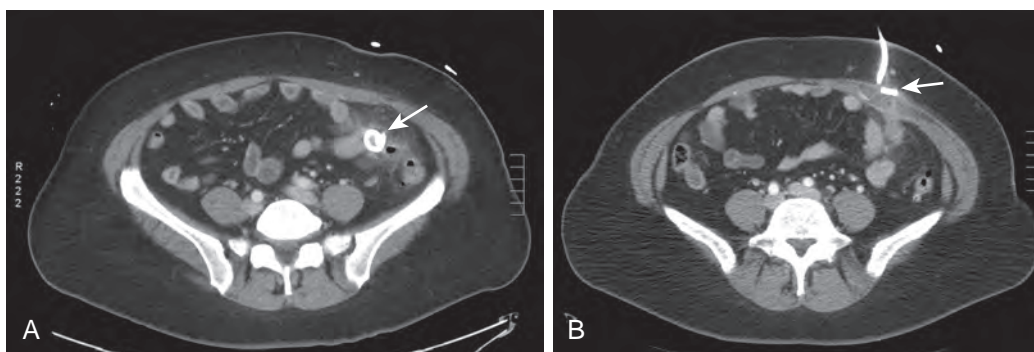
Catheter dislodgment after percutaneous drainage. A. Axial CT image shows a left lower quadrant percutaneous drainage catheter placed in a 65-year-old man with diverticular abscess. The catheter tip is in the appropriate position within the abscess (arrow). The patient presented 2 weeks later with decreasing drainage from the catheter. B. Follow-up CT showed that the catheter had retracted from an intra-abdominal location into the subcutaneous tissues (arrow). The catheter was successfully repositioned into the abscess under fluoroscopic guidance.
